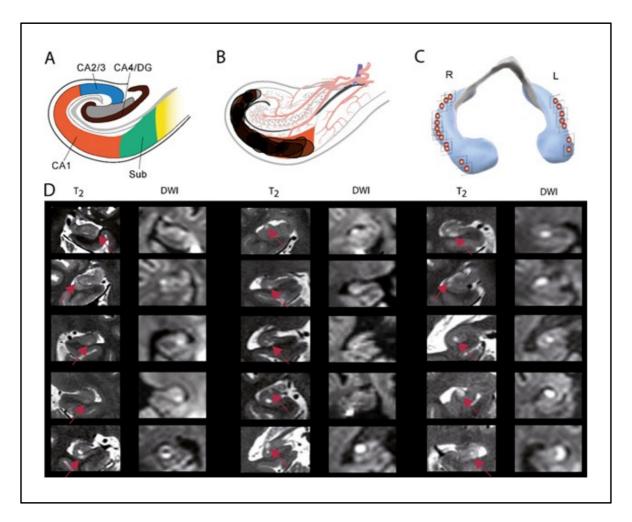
a-d) a) Anatomical template showing a representative coronary slice of the hippocampal cornu ammonis indicating sectors after Lorente de Nó. b) Synopsis of all DWI/T2 lesions transferred to an anatomical template of the cornu ammonis. c) Three-dimensional model of the hippocampus showing the anterior-posterior distribution of hippocampal CA1 lesions. Lesions were located in the lateral hippocampus and were distributed along the anterior-posterior axis of the hippocampus. d) MRI of representative lesions shows that lesions were confined to the CA1 area of the cornu ammonis.
